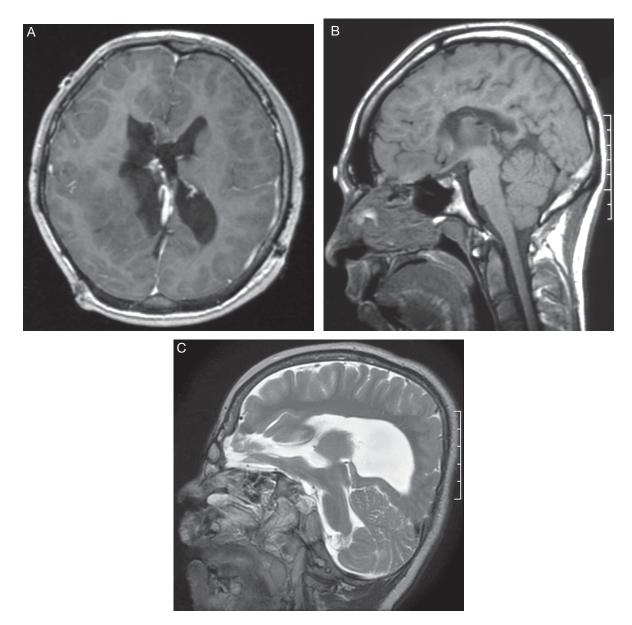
Agenesis of Corpus Callosum on Magnetic Resonance Imaging.
